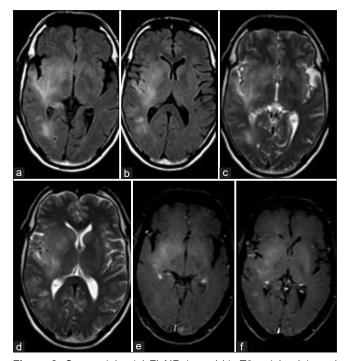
Sequential axial FLAIR (a and b), T2-weighted (c and d) and post-contrast T1-weighted (e and f) MRI done at the time of initial presentation showing focal areas of high signal intensity on T2-weighted and FLAIR images in the right temporal lobe with mild mass effect along with mild contrast enhancement. FLAIR = Fluid-attenuated inversion recovery; MRI = Magnetic resonance imaging
